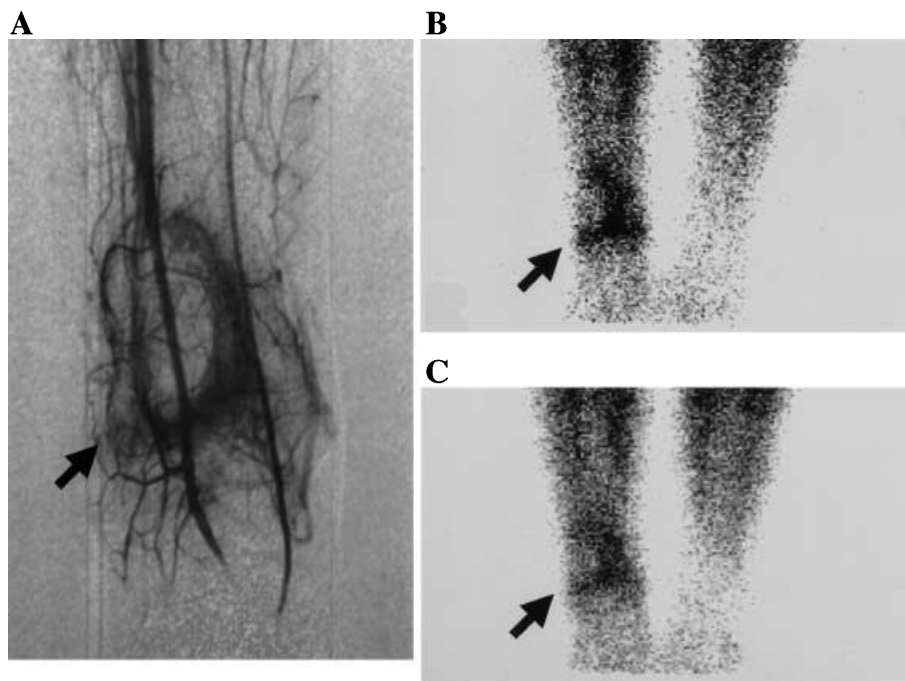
An 18-year-old woman (case 14, Table 1) with a history of aneurysmal bone cyst in the distal right tibia. Angiography demonstrates a hypervascular area in the inside of the outer border of the tumor (arrow) (A). ²⁰¹Tl scintigraphy reveals ringlike accumulation in the hypervascular area (arrows) (B, early image; C, delayed image)
